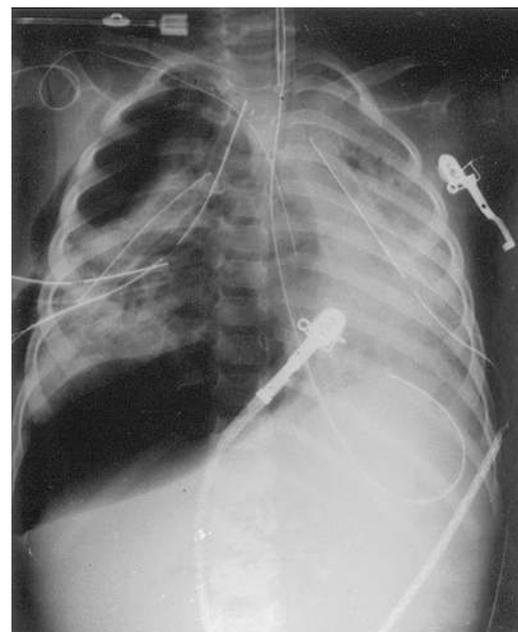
Chest Radiograph Showing Tension Pneumothorax in a Patient with Acute Respiratory Distress Syndrome.
